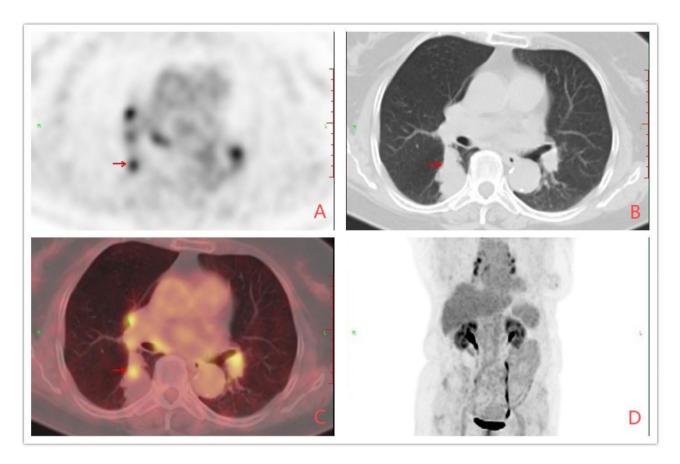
18 F-FDG PET/CT demonstrated elevated FDG uptake in the proximal region of the mass, with a maximum standardized uptake value (SUVmax) of 5.1, while no increased FDG uptake was observed in the distal area
